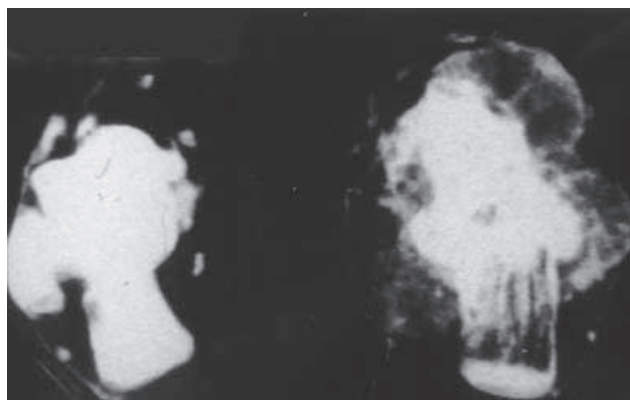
Computed tomogram which reveals the talus was replaced by low density mass invaded into the soft tissue.
